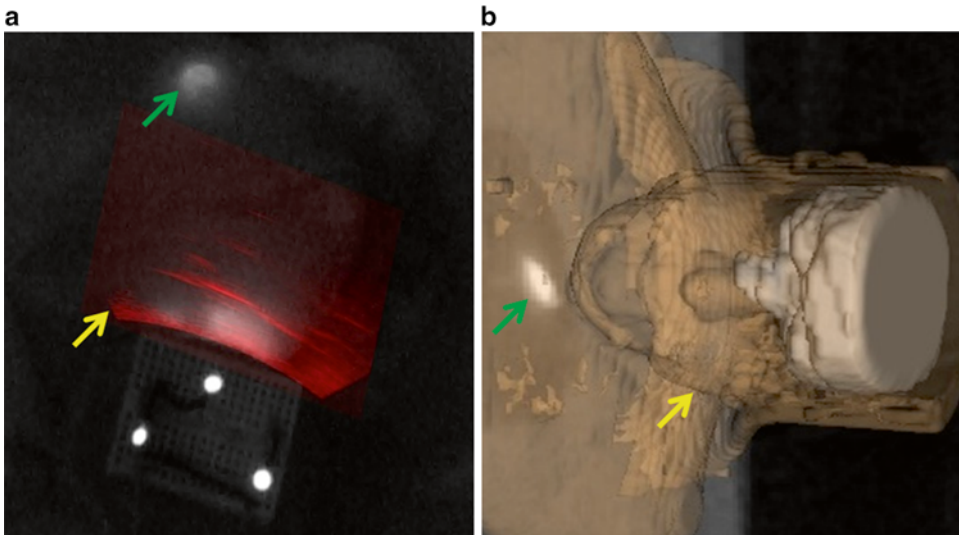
Integrated Imaging goggles enables multimodal imaging and intraoperative fluorescence imaging registered with preoperative tomography-based surgical navigation. (a) Overlaid image of intraoperative ultrasound data registered with intraoperative fluorescence imaging data in preclinical studies is shown. *Yellow arrow* indicates B-mode ultrasound data; *green arrow* indicates lesions with high fluorescence intensity. (b) Overlaid image of preoperative MRI data registered with intraoperative fluorescence imaging data in proof-of-concept studies is shown. *Yellow arrow* indicates preoperative MRI surgical navigation data; *green arrow* indicates lesions with high fluorescence intensity from tissues
